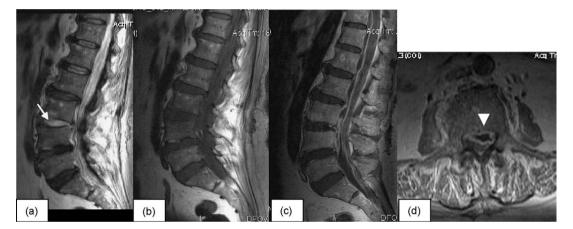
Initial MRI from patient 6: sagittal T2 (a), T1 (b), and post-gadolinium sagittal (c) and axial (d) T1 images show increased signal of the L3–L4 intervertebral disc (arrow), bone marrow edema of the adjacent vertebral bodies, and contrast enhancement of the vertebral body. There is paraspinal infection and extension of the infection to the epidural space up to the level of T11, producing canal stenosis (arrowhead).
